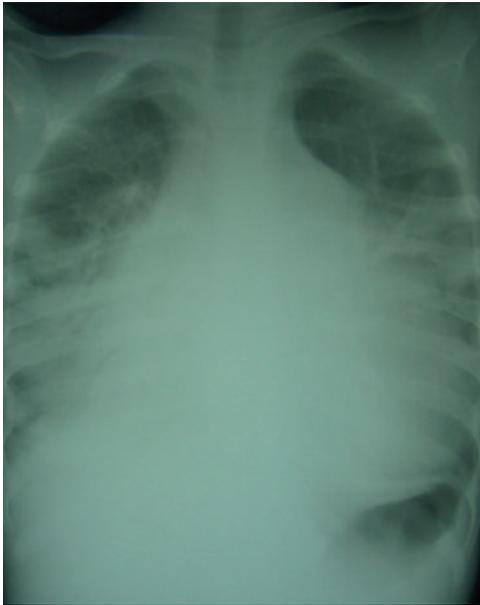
Chest x-ray demonstrating heart failure due to rheumatic heart disease.
